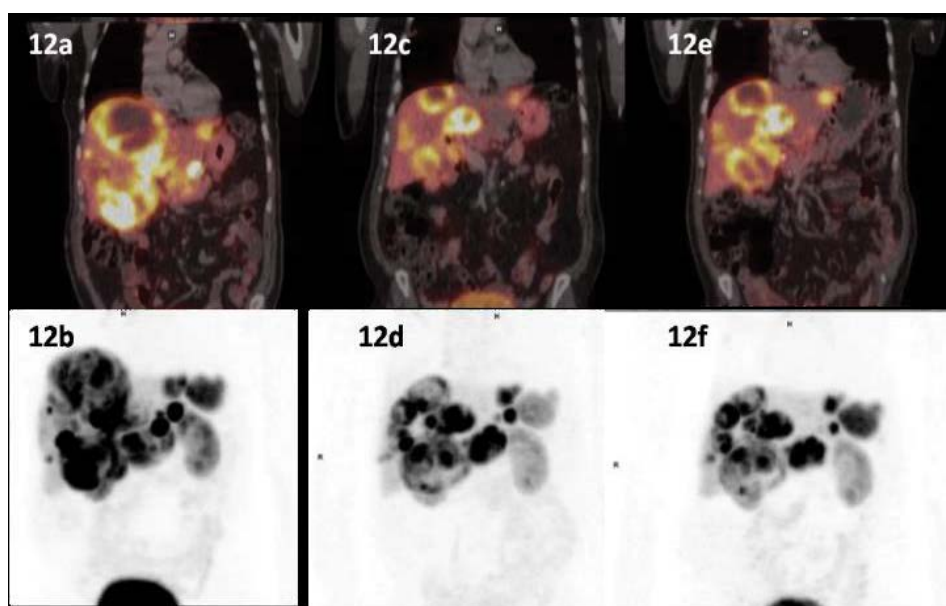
a & d) Patient 3 had multiple bulky SSR avid hepatic metastasis, with few extrahepatic sites of low grade SSR avid disease in the mesentery, right lung and mediastinum. b & e) Patient 3 Post 2nd cycles of IA infusion PRRT, ^{68}Ga -DOTANOC PET CT showed significant decrease in the size of most of the liver lesions with interval necrosis. c & f) Patient 3 Further decrease in size of the liver lesions with decrease in metabolic activity seen after 4 cycles of IA infusion PRRT suggestive of partial response.
